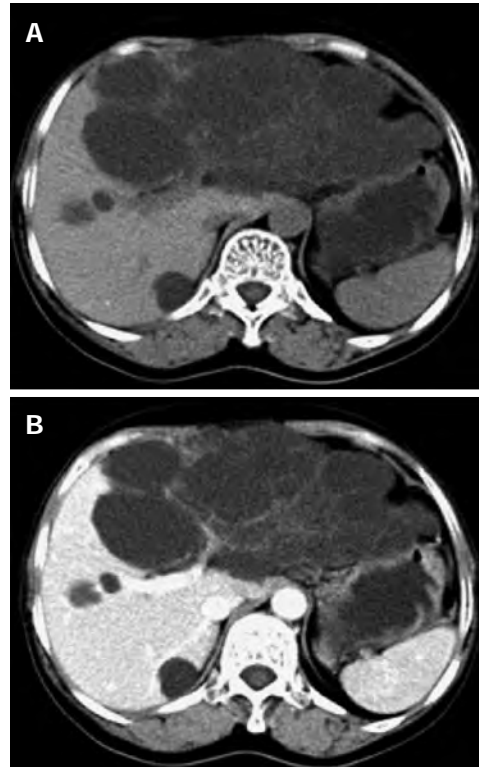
Transverse computed tomography scan showed a left hepatic multiloculated cystic mass measuring 15.0 cm × 9.1 cm (A) and contrast computed tomography showing enhanced septum of the tumor (B). Simultaneously, multiple sizes of hypoattenuating shadows without enhancement were seen in the right liver lobe.
